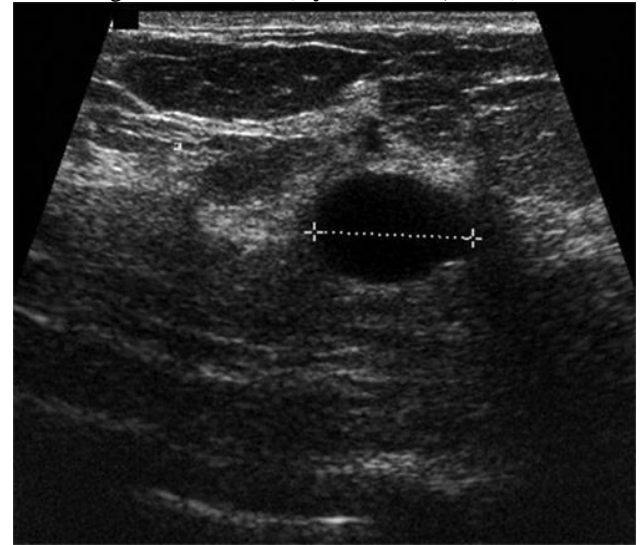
US images in 57-year-old woman with infiltrating ductal carcinoma at core biopsy. (a) B-mode image shows an irregular hypoechoic mass. (b) US elastographic image shows the entire lesion as blue, indicating a hard lesion. (c) Color Doppler US image shows increased vascularity. At the first reading session (B-mode alone), three readers classified the lesion as a likelihood of malignancy score of 3 (intermediate suspicion), and two readers classified the lesion as a likelihood of malignancy score of 4 (moderate suspicion). At the fourth reading session (B-mode, elastography, and Doppler US), all five readers upgraded it to a likelihood of malignancy score of 5 (high suspicion) (Cho et al; 2012).
